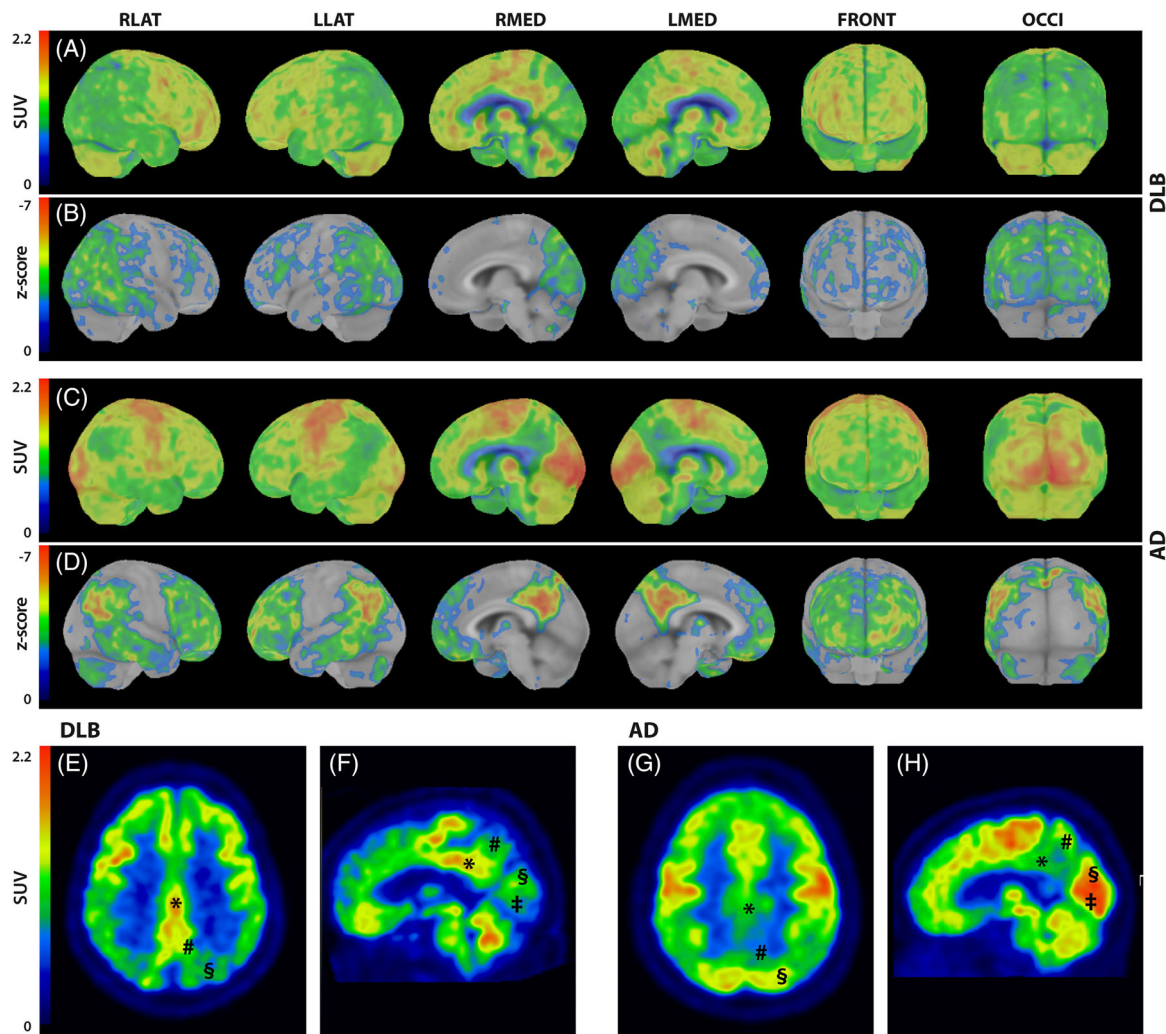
¹⁸F-FDG-PET. (A-D) Surface projection and z-score maps of ¹⁸F-FDG-PET. (A) Representative ¹⁸F-FDG-PET of a DLB patient with distinct hypometabolism in the lateral and medial occipital cortex, temporoparietal cortex, and lateral frontal cortex. (B) Corresponding Z-score maps of the DLB patient with a threshold of -2 standard deviations compared to a normal cohort. (C) Representative ¹⁸F-FDG-PET of an AD patient with distinct hypometabolism in the temporoparietal cortex, posterior cingulate cortex, precuneus, and lateral and medial frontal cortex. (D) Corresponding Z-score maps of the AD patient with a threshold of -2 standard deviations compared to a normal cohort. (E-H) Cingulate island sign. (E-F) ¹⁸F-FDG-PET of a DLB patient in axial (E) and sagittal (F) plane with a severe hypometabolism in the precuneus, visual cortex, and occipital lateral cortex, while ¹⁸F-FDG uptake is relatively preserved in the posterior cingulate cortex. (G, H) ¹⁸F-FDG-PET of an AD patient in axial (G) and sagittal (H) plane with a severe hypometabolism in the posterior cingulate cortex, while ¹⁸F-FDG uptake in the visual cortex and occipital lateral cortex is relatively preserved. AD, Alzheimer’s disease; DLB, Dementia with Lewy Bodies; OCLAT, lateral occipital cortex; PCC, posterior cingulate cortex; PREC, precuneus; SUV, standard uptake value; VC, visual cortex; RLAT, right lateral view; LLAT, left lateral view; RMED, right medial view; LMED, left medial view; FRONT, frontal view; OCCI, occipital view
